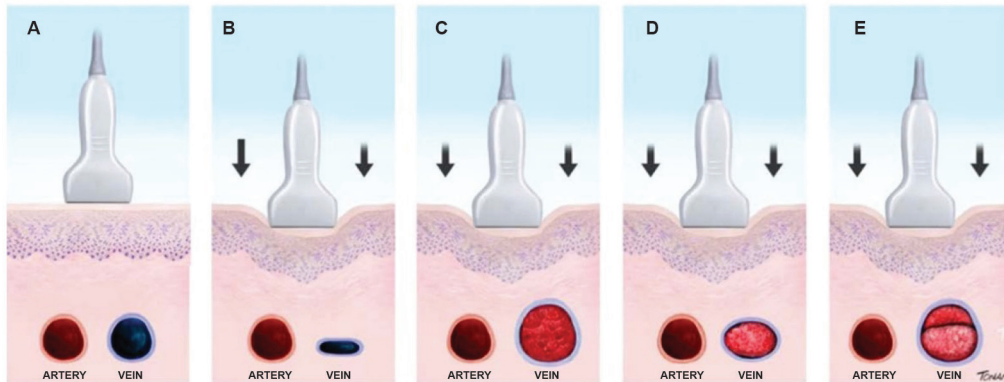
A-E: Venous compressibility evaluation by the ultrasound transducer in the investigation of venous thrombosis. A: artery and vein without transducer compression. B: normal vein with maximum compression. C: dilated and noncompressible vein with acute/fresh thrombus. D: normal- to small-caliber vein, slightly compressible by transducer maneuvers and consistent with findings of chronic/old venous thrombosis. E: recurrent thrombosis.
